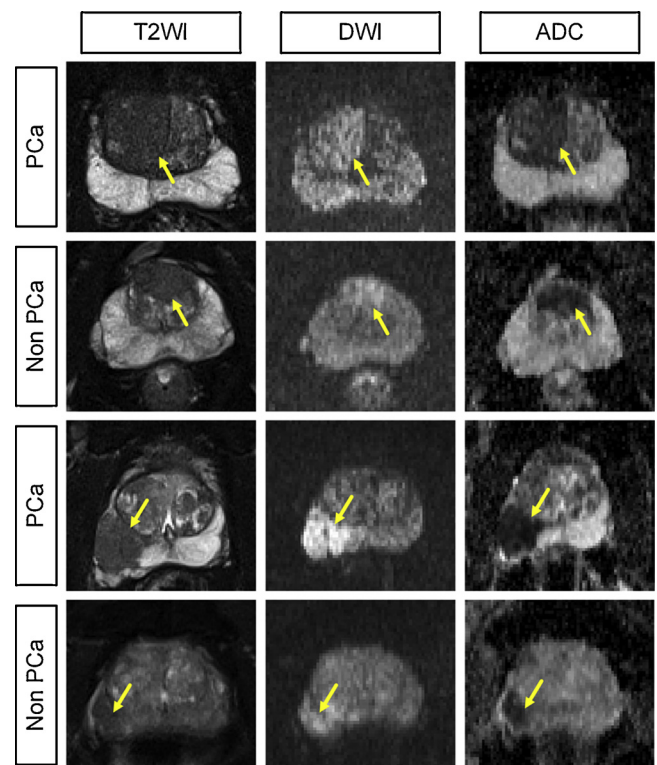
Axial images of predicted samples in bi-parametric MR images and the four patients had different pathological results.
